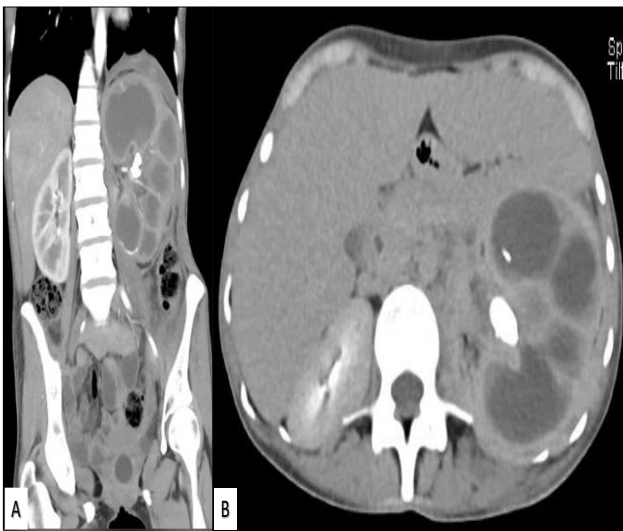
(A and B): XP. Coronal section of CT. Left kidney with increased dimensions, altered morphology and loss of sinus-parenchyma relationship. Parenchyma with homogeneous enhancement of the cortex. In the renal pelvis, an image is observed that adopts its morphology, hyperdense, corresponding to renal lithiasis. Axial section of CT, where data of XP can be observed in the left kidney, as well as the presence of a stone in the renal pelvis.
